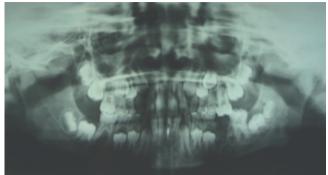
Panoramic radiograph demonstrates left mandibular radiolucent lesion extending from sigmoid notch to the inferior border
